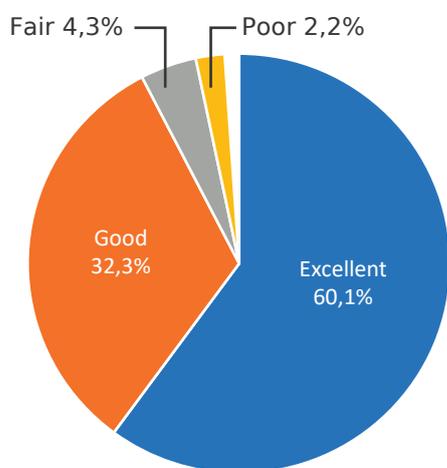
Patient experience with CT colonography
